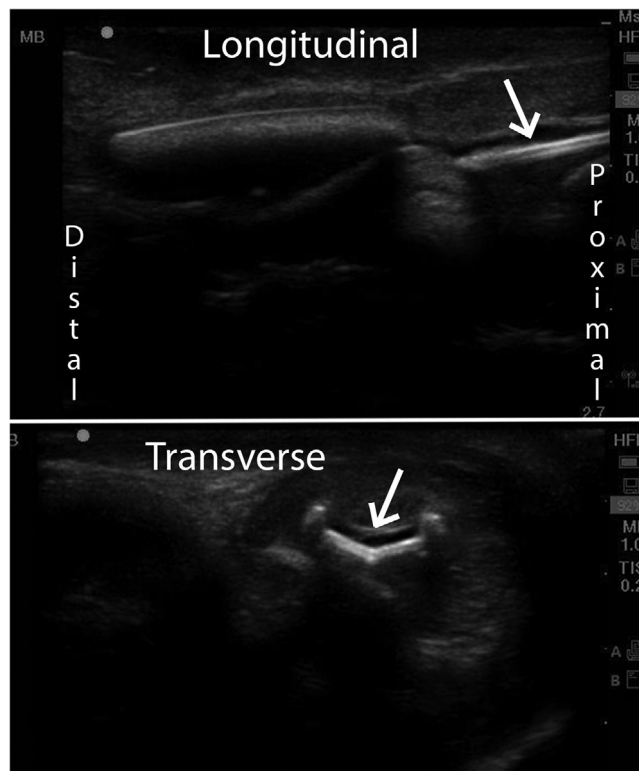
Ultrasound examination of a urethral foreign body in longitudinal and cross-sectional views. The object shown is a plastic spoon handle
